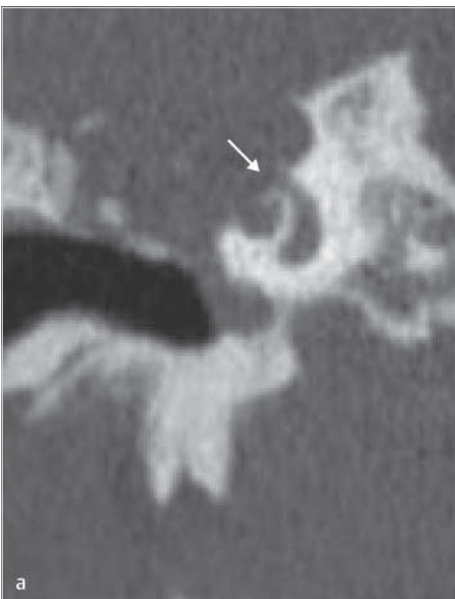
In spite of good inner ear function, and modest otoscopic findings, the coronal CT scans show extensive erosion in the cochlea (white arrow), semicircular canals (red arrows), and the internal auditory canal (yellow arrow).
